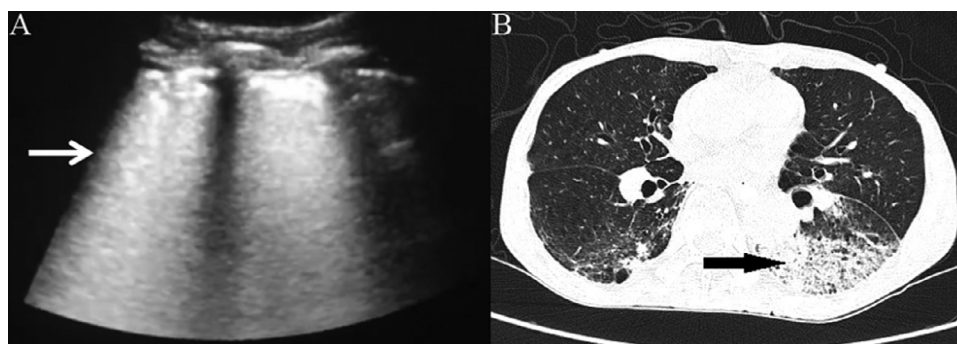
Sonographic and computed tomography (CT) images of a patient with severe coronavirus disease 2019 (COVID-19) showing a diffusely B line (*arrow*) on ultrasound (A) and ground-glass opacity (*arrow*) on CT (B).
